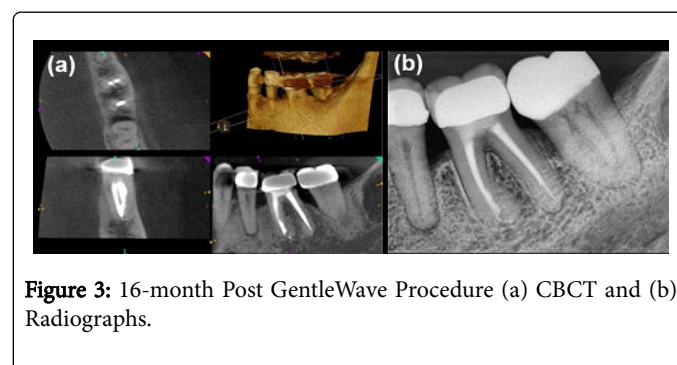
16-month Post GentleWave Procedure (a) CBCT and (b) Radiographs.
